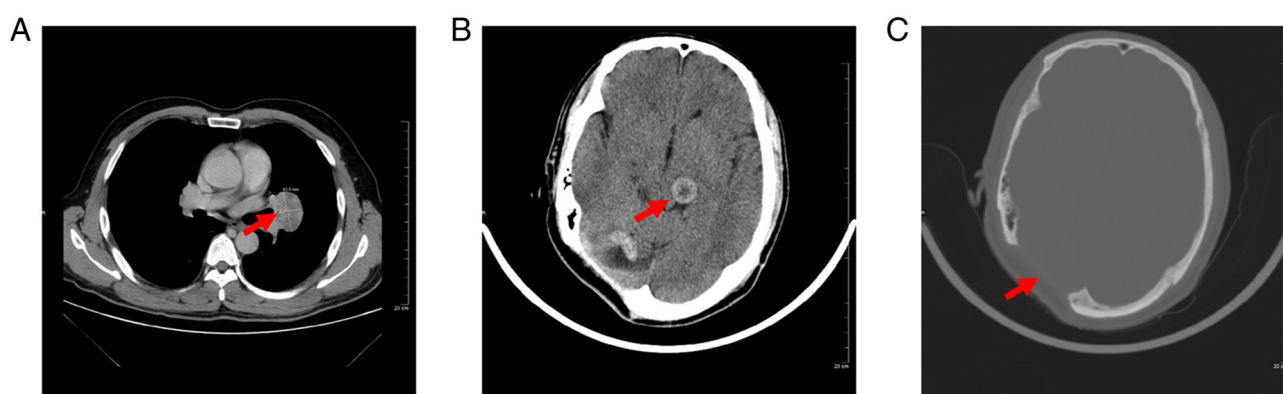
CT images prior to the puncture biopsy in 2017. (A) CT indicating a heterogeneously enhanced lung mass measuring up to 44x31 mm in the left upper lobe near the hilum. The arrow indicates the lung mass. (B) Preoperative CT revealed a heterogeneously enhanced round mass measuring up to 31x21 mm in the left thalamus. The arrow indicates the left thalamic mass. (C) CT (bone window) indicated a cavity after resecting the brain tumor and no local recurrence (scale bar, 20 cm). The arrow indicates the cavity after resecting the brain tumor.
